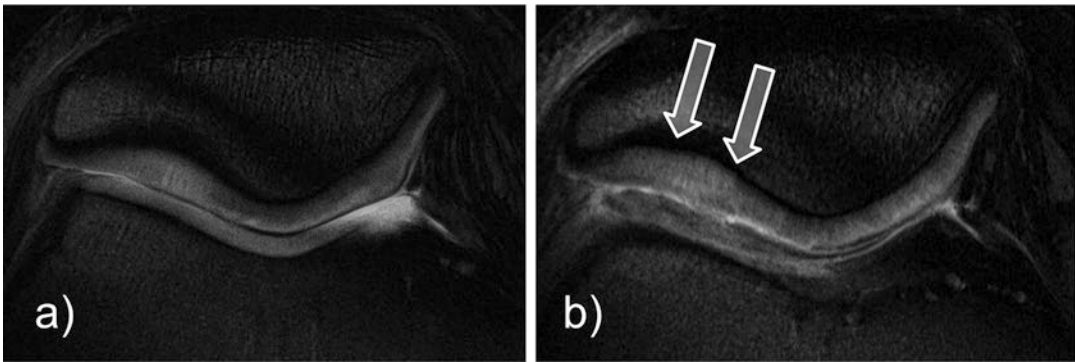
Very-high-resolution morphological fsPD-TSE axial MR images of the patellofemoral joint as performed on a 7.0 Tesla MRI with an in-plane resolution of 0.2×0.2 mm. The left image (a) shows normal healthy
